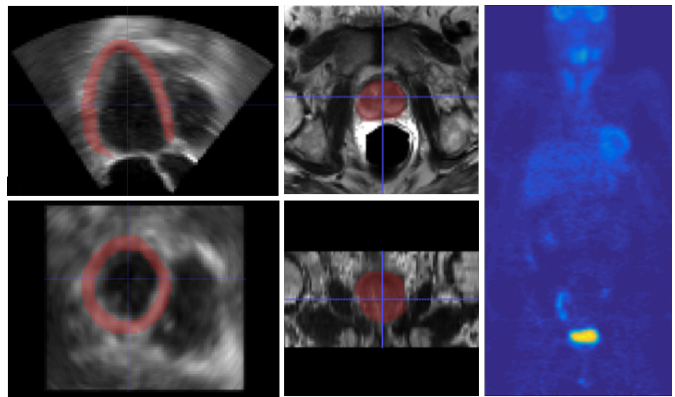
Samples of the used datasets. The first column shows the left ventricular myocardium (highlighted in red) in ultrasound echocardiography. In the second column, the prostate is highlighted in red in an MRI scan. For MRI and ultrasound samples, the 2 rows show the axial and coronal views. Column 3 shows coronal view of a whole body PET scan.
